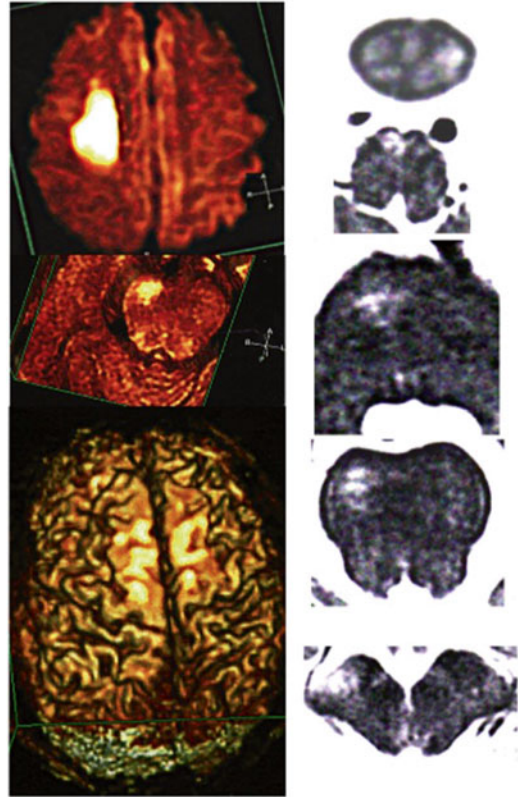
Tracing the extent of Wallerian degeneration of the corticospinal tract with MRI in a patient with a chronic right parietal subcortical infarct
